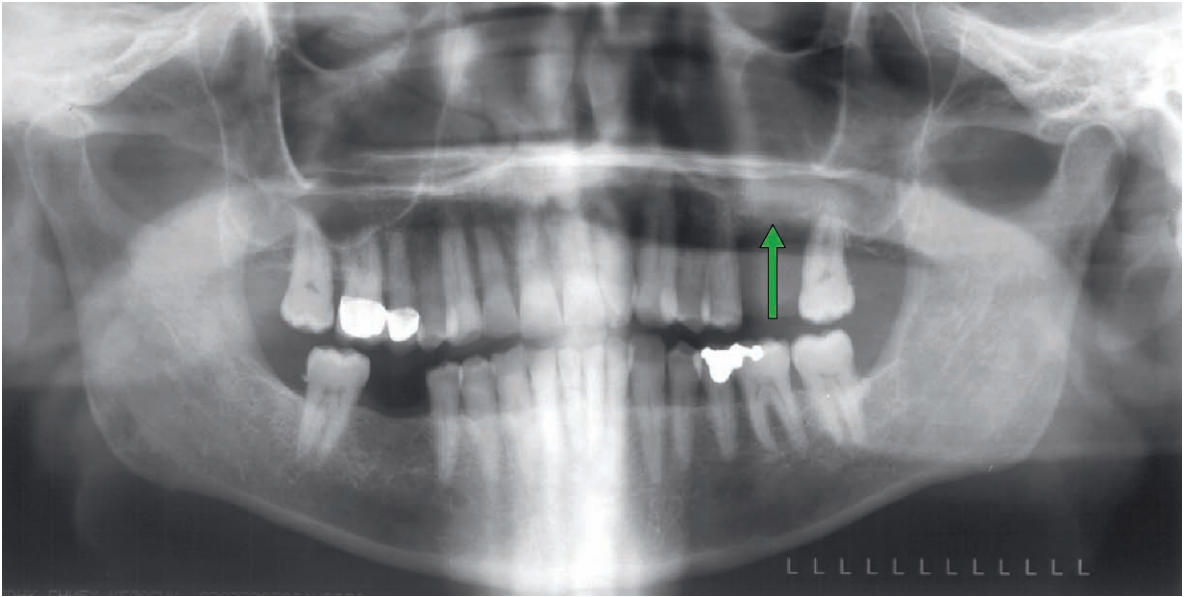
Panoramic radiograph of maxillary squamous cell carcinoma. There is a loss of the lower cortex of the sinus (*arrow*); however the feature is relatively subtle in this view
